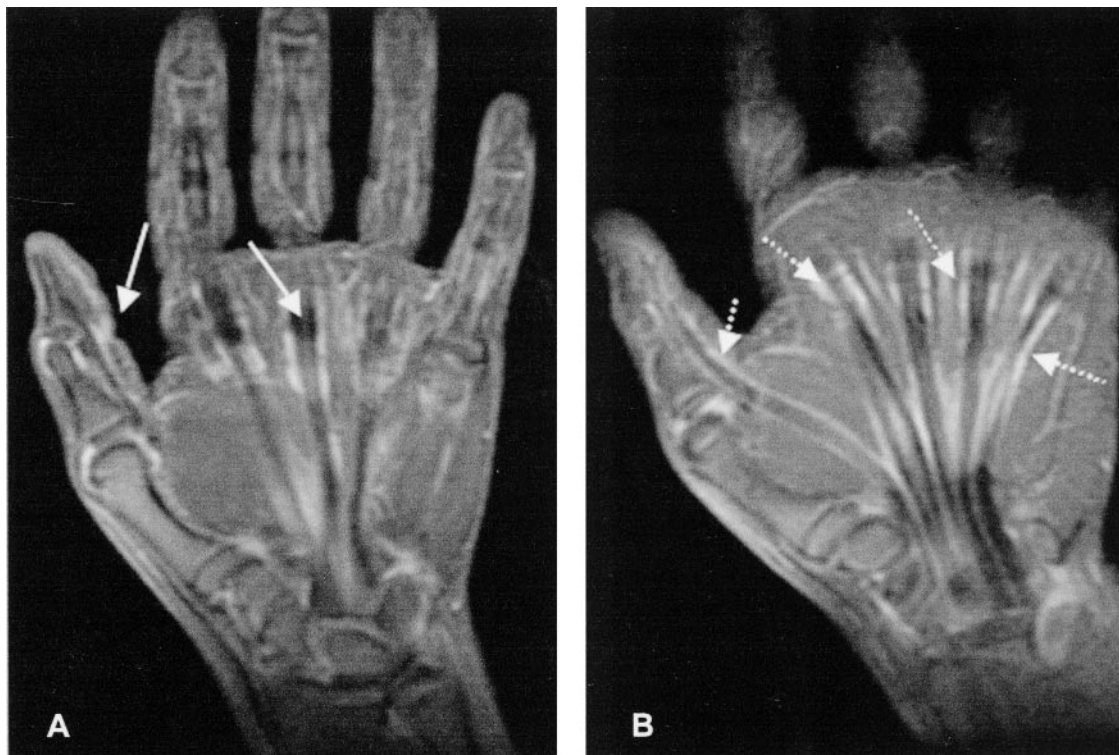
Coronal fat suppressed T1-weighted image (400/14 TR/TE, 4/1 slice thickness mm/gap thickness mm, 256 × 160 matrix, 18 cm FOV) of the hand and wrist with intravenous contrast of a 12-year-old boy (Patient 2) with increased synovial enhancement of all regions. Note the tenosynovitis (arrows) at initiation of the study (A). After 3 months (B), there was no significant change in the volume of synovium surrounding the flexor tendons (broken arrows).
